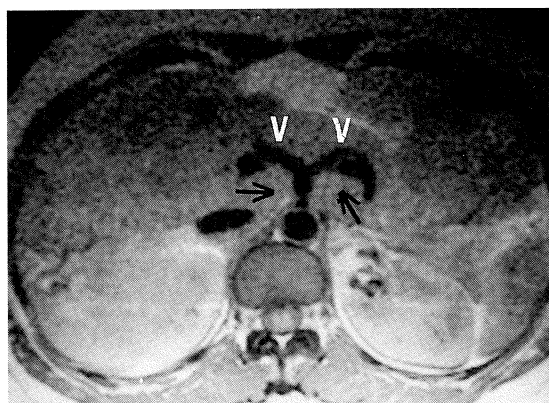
Magnetic resonance imaging (MRI), showing numerous large lymph nodes around the coeliac axis (arrows) causing splaying with the sea gull sign (arrowheads).
